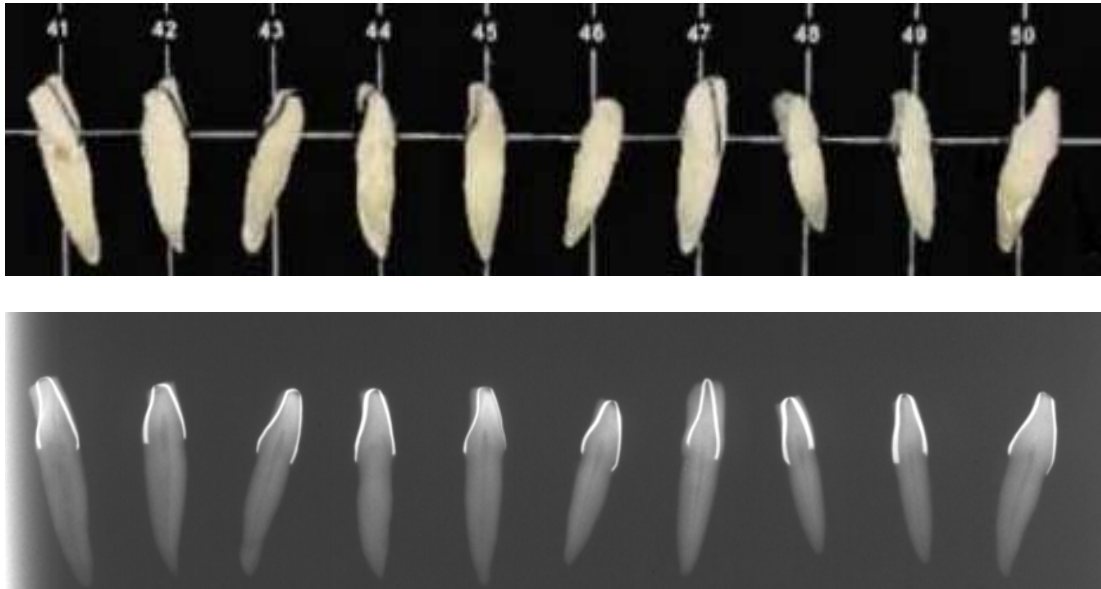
The radiographic images provided by the radiographic markers on rotated teeth numbers 41-50.
